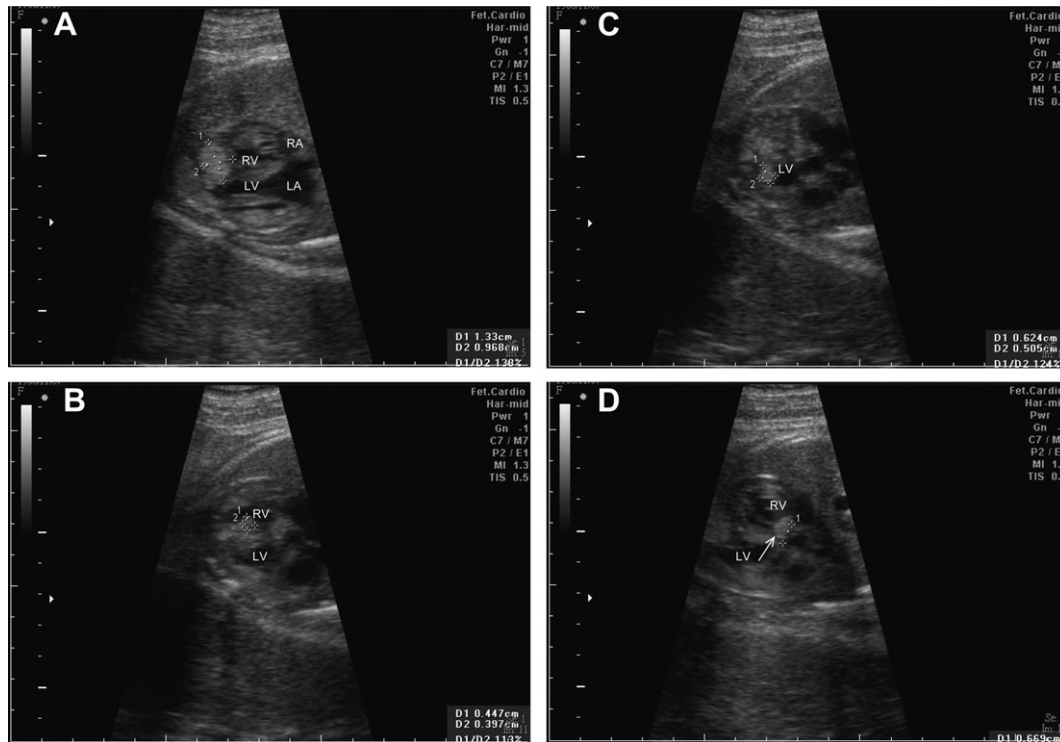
Prenatal ultrasound of the heart at 34 weeks of gestation shows (A) a 1.33 cm \times 0.968 cm tumor in the lowest part of the interventricular septum (IVS) near the apex; (B) a 0.447 cm \times 0.397 cm tumor in the middle part of the IVS; (C) a 0.624 cm \times 0.505 cm tumor in the wall of the left ventricle; and (D) a 0.669 cm tumor in the left ventricle outflow tract. LA = left atrium; LV = left ventricle; RA = right atrium; RV = right ventricle.
